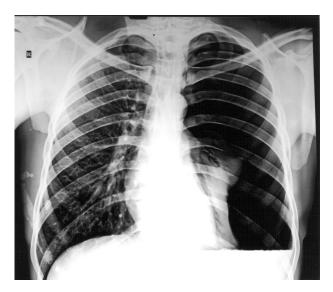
Chest radiograph (postero-anterior view) showing the left-sided pneumothorax and collapsed lung.
